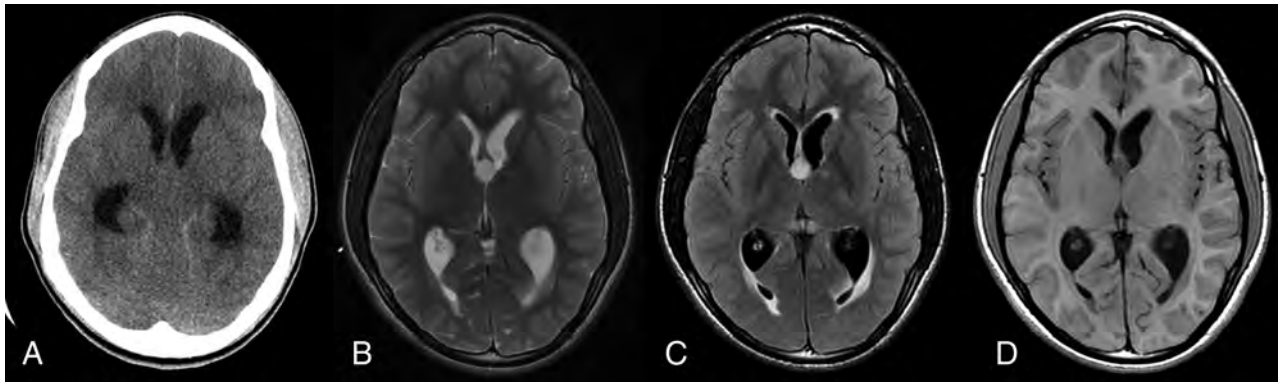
Homogeneously hyperintense cyst: 13-year-old boy found unconscious after complaining of headache for 2 days. Initial CT demonstrates dilation of the lateral ventricles. However, the colloid cyst was difficult to detect as it was isointense relative to the adjacent brain. Subsequent MR imaging showed a colloid cyst homogeneously hyperintense on T2 (B) and T2-FLAIR weighted images (C) and hypointense on T1-weighted axial image (D). Also, note the presence of periventricular edema associated with ventriculomegaly.
